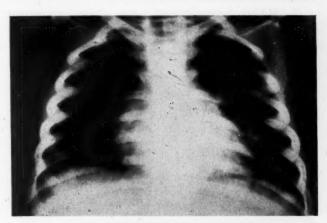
The chest x-ray taken four days before death.
